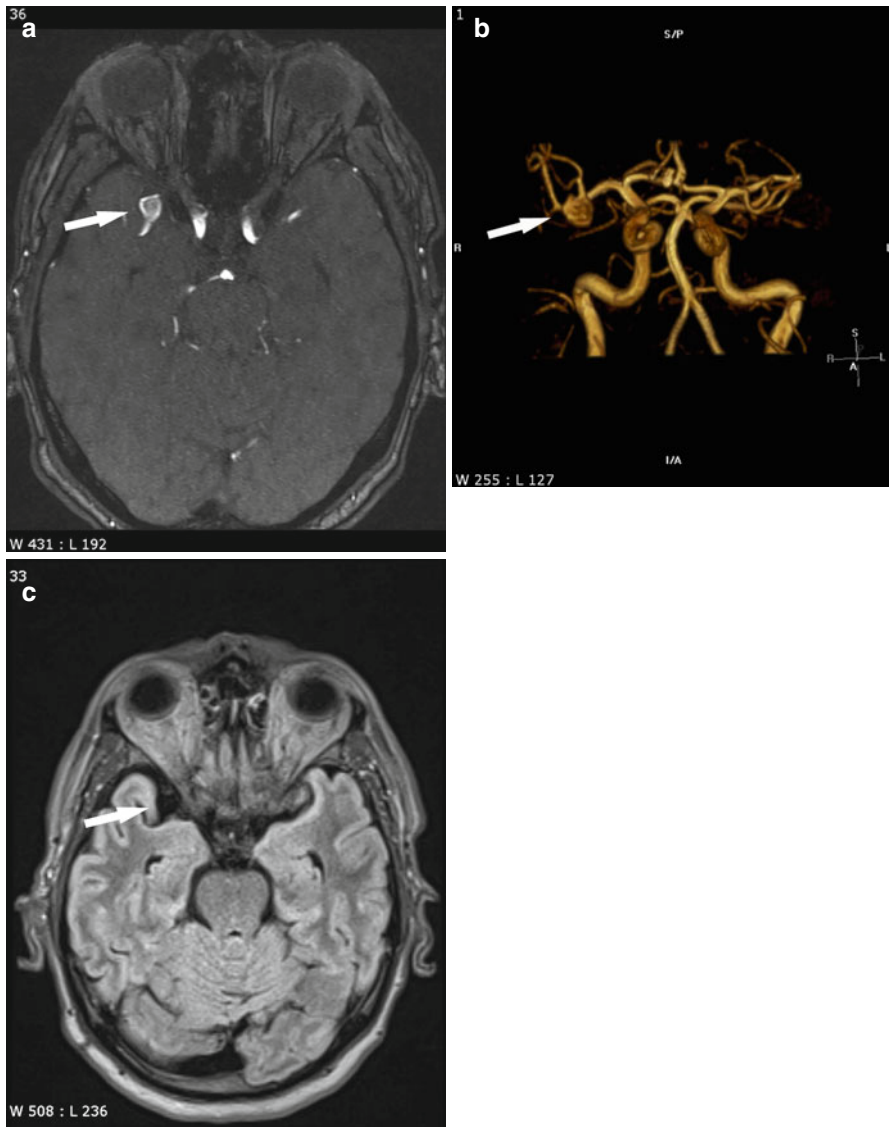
Right-sided middle cerebral artery bifurcation aneurysm (*arrow*) on TOF (a) and VRT (b) images. The FLAIR image (c) shows normal flow void
